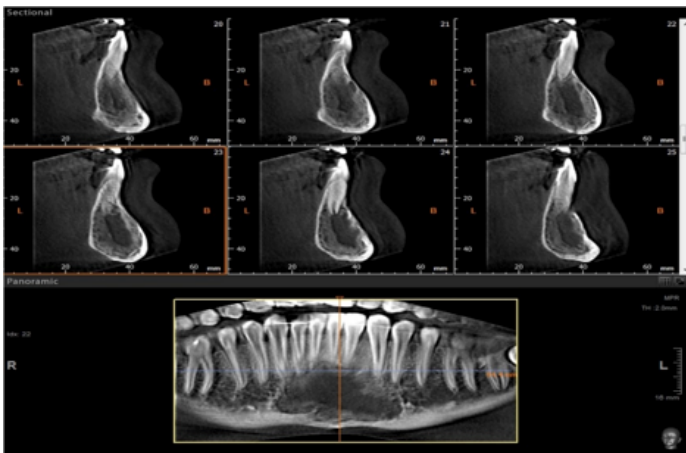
Showing bone healing occurred within 5 months on CBCT scan. The patient recovered uneventfully. The patient still follow-up in long-term period due to the possibility of recurrence.
